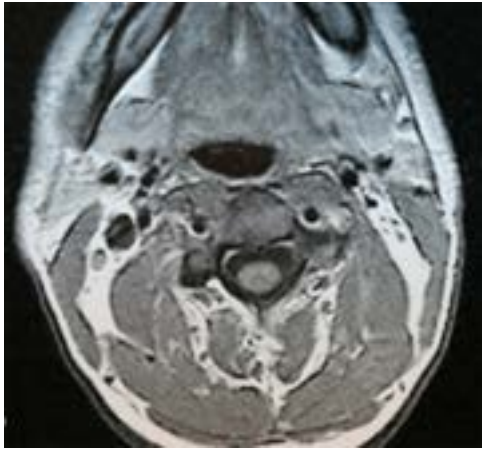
Postoperative MRI after 6 years showing patient to be disease free.
